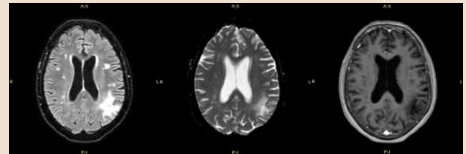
Brain FLAIR (left), DWI (middle) and contrast-enhanced (right) MR sequences showing PML left parietal-occipital lesion at the diagnosis.
